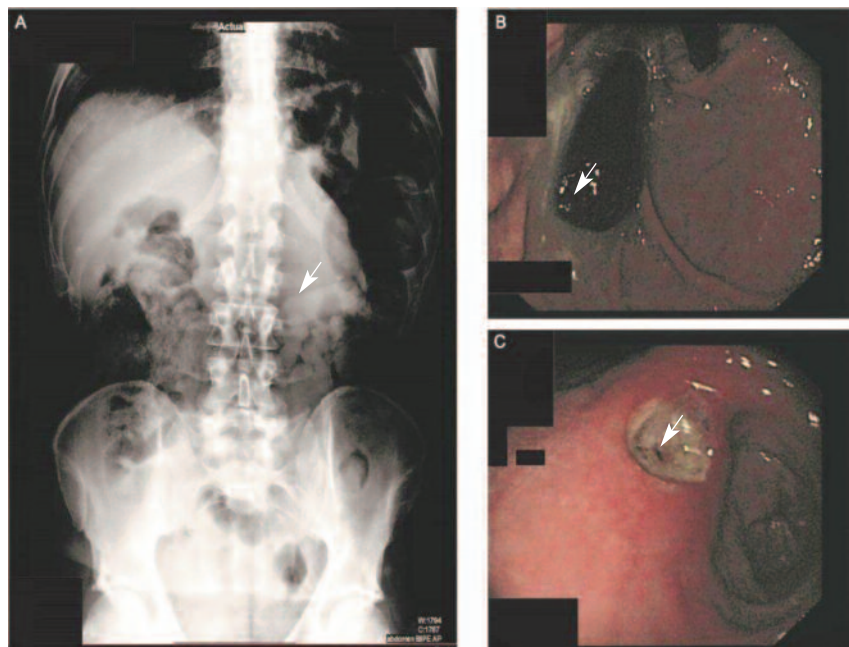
A) Simple abdominal x-ray showing an oval object in the upper left quadrant (arrow). B) Upper digestive endoscopy: oval foreign body in gastric fundus (arrow). C) Gastric ulcer at the level of angular incisura with regular edges and 7 mm maximum diameter (arrow).
